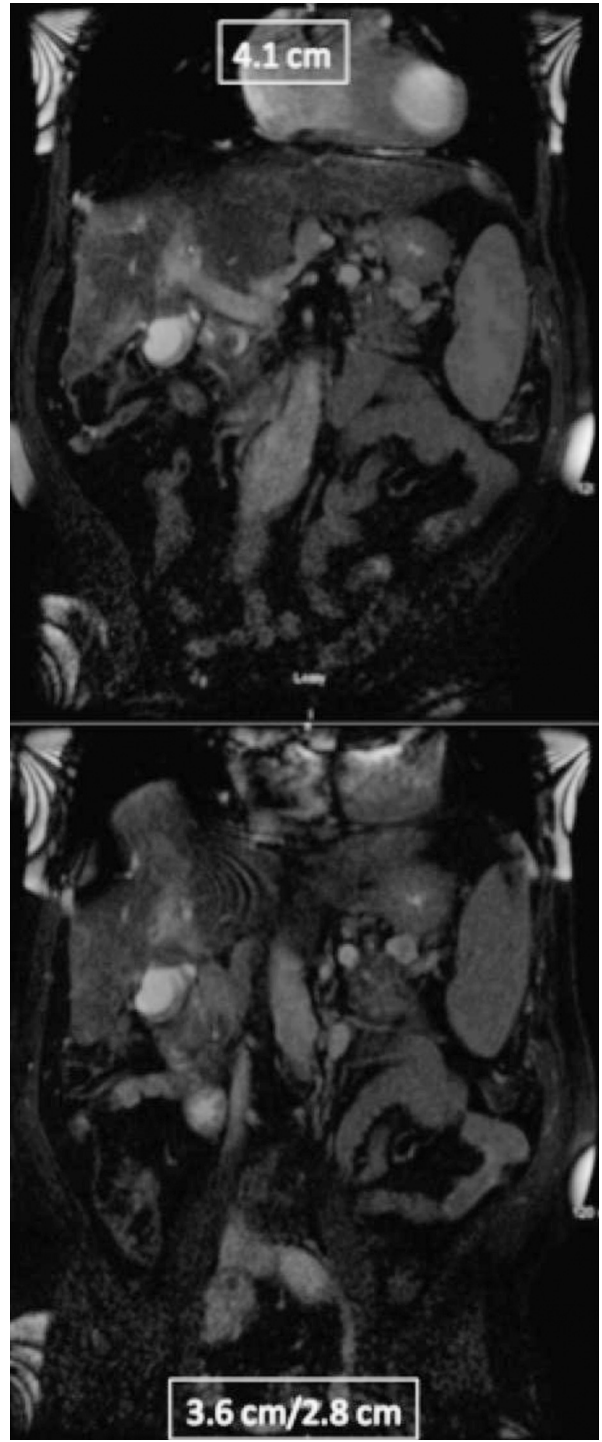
Magnetic resonance imaging abdomen and pelvis, April 2014.
